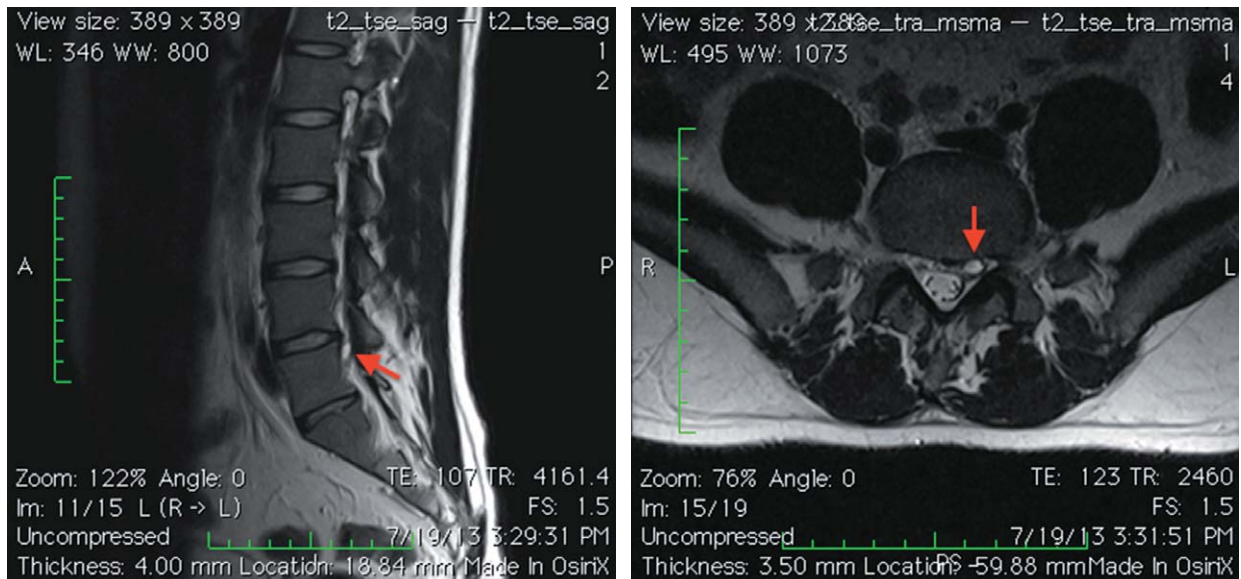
Lumbar spine T2-weighted sagittal (A) and axial (B) magnetic resonance imaging (MRI) scans showing a 7 × 4-mm cystic lesion (red arrows) with well-defined contours (perineural cyst) in close proximity with the left L5 root. [Color figure can be viewed in the online issue, which is available at wileyonlinelibrary.com.]
